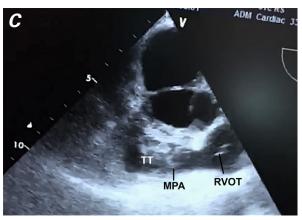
Transthoracic echocardiograms show A) a 35 × 27-mm mass in the inferior vena cava (IVC) and right atrium (RA), B) the cephalad movement of the intra-atrial tumor thrombus (TT) into the tricuspid valve (TV), and C) the thrombus embolized in the main pulmonary artery (MPA).
